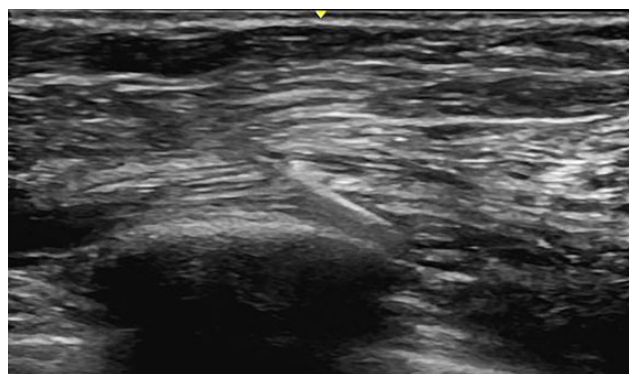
Ultrasound image of a deep serratus plane block.
